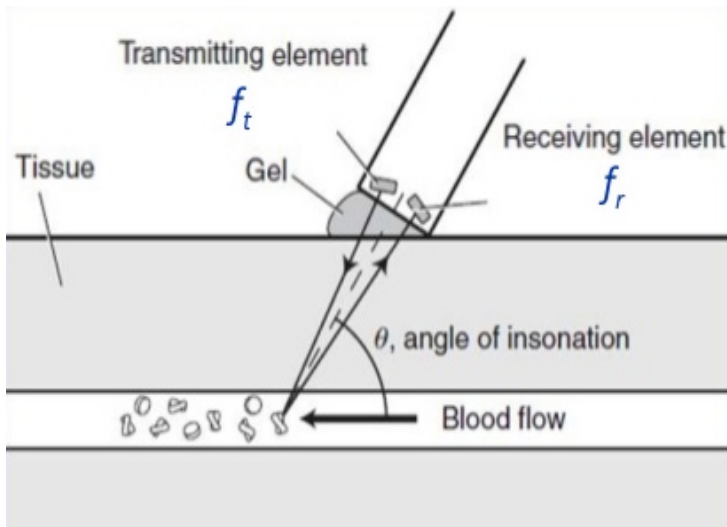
Example of the Doppler shift. The frequency difference between the transmitted signal (f_t) and the receiving signal (f_r) is used to determine the direction and velocity of the red blood cells.
